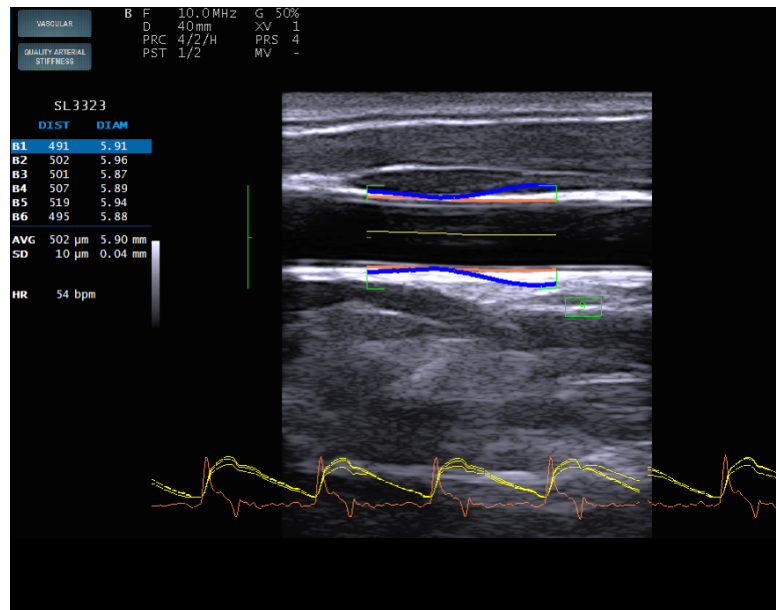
ULTRASOUND EVALUATION OF DISTENSIBILITY WITH RADIOFREQUENCY ECHOTRACKING.
